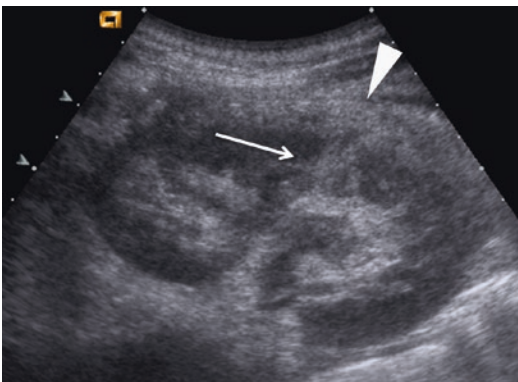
Ultrasound shows injured left kidney, with a hyperechoic parenchymal area at the medium of the kidney, corresponding to the lesion (*arrow*); there is a hyperechoic hematoma surrounding the kidney (*arrowhead*)
